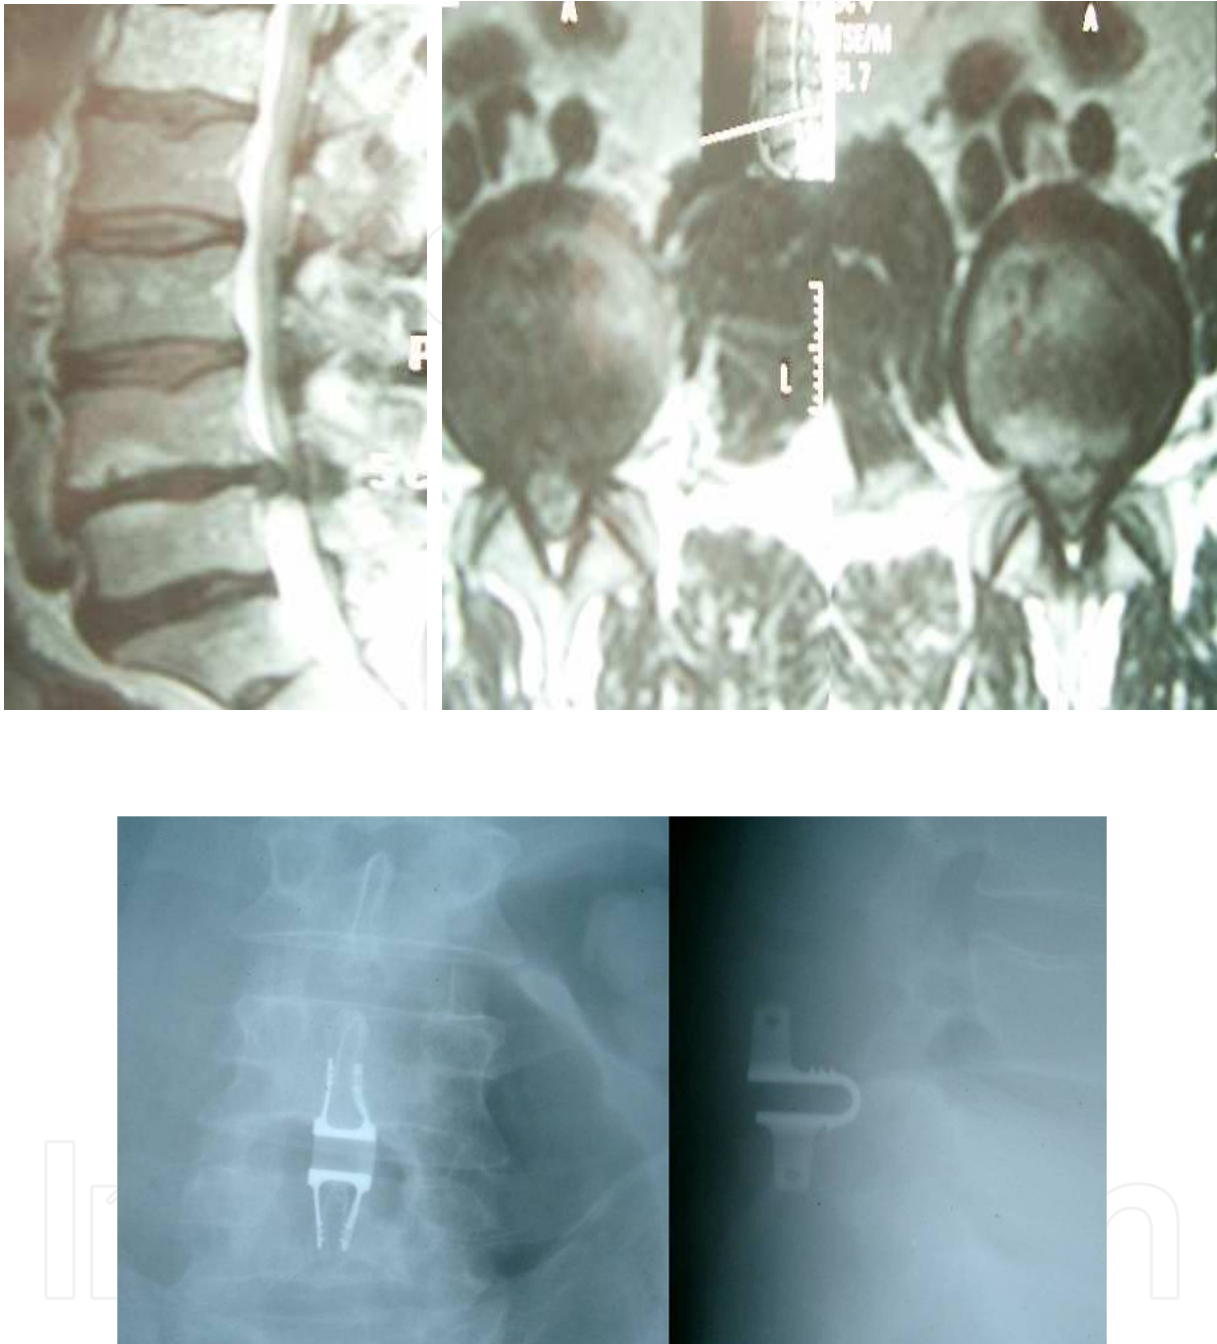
L4-L5 diffuse protrusion and bilateral foraminal stenosis on preoperative MRI of a 55 year old men, whom had low back and bilateral leg pain which dominate at right side with numbness and causalgia during last 6 months, was shown. At physical examination bilateral muscle weakness at ankle dorsiflexion and L4-S1 hypoesthesia were obtained. Postoperative anteroposterior and lateral X-rays of the case was shown. The interspinous device (Coflex) was applied at L4-L5 level after discectomy posteriorly to preserve the height of the interspinous foramina (Karabekir, 2005).
